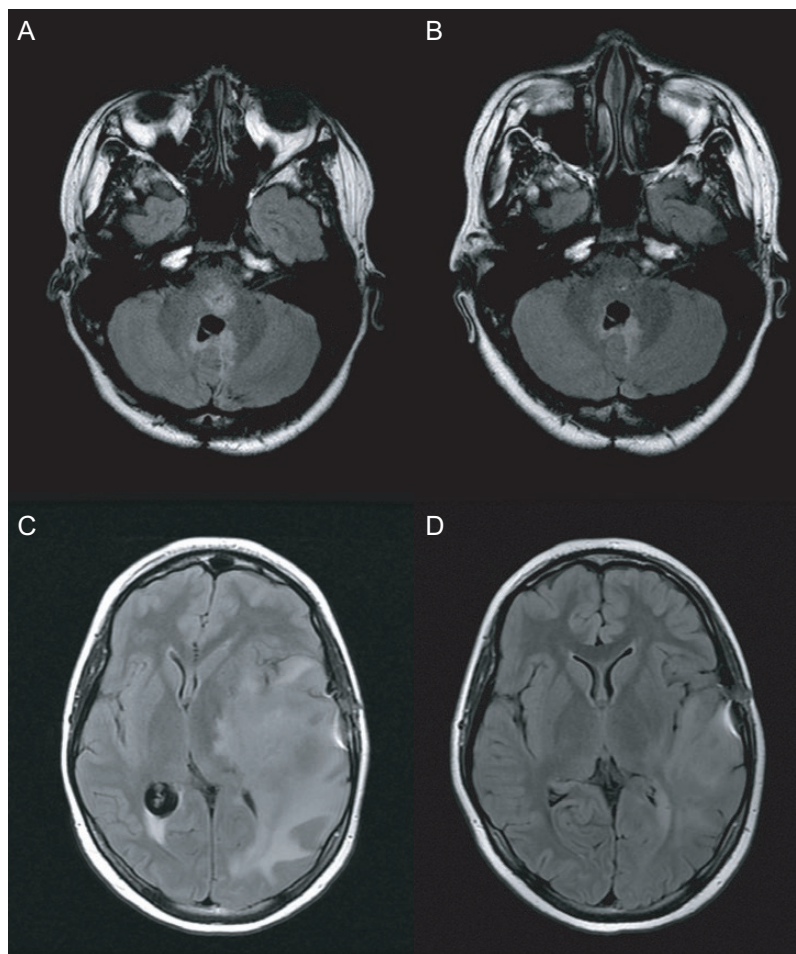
Case 8: Axial fluid-attenuated inversion recovery (FLAIR) MRI of a posterior fossa type A ependymoma presenting with late radionecrosis 9 years after completion of radiation at A, diagnosis and B, after 4 doses of bevacizumab. Case 9: Axial FLAIR MRI of a high-grade glioma 2 months postradiotherapy presenting with radionecrosis at C, diagnosis and D, after 6 doses of bevacizumab.
